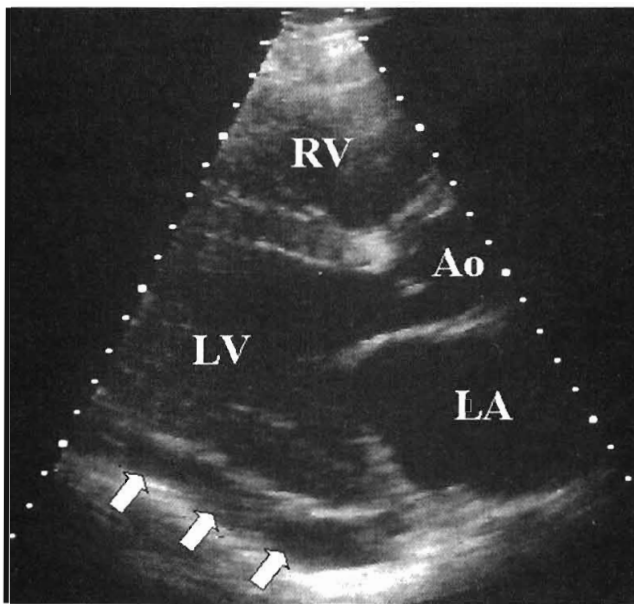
Echocardiographic findings in a small-moderate pericardial effusion (*white arrows*). Long-axis parasternal view. LV, left ventricle; LA, left atrium; RV, right ventricle; Ao, aortic root.
